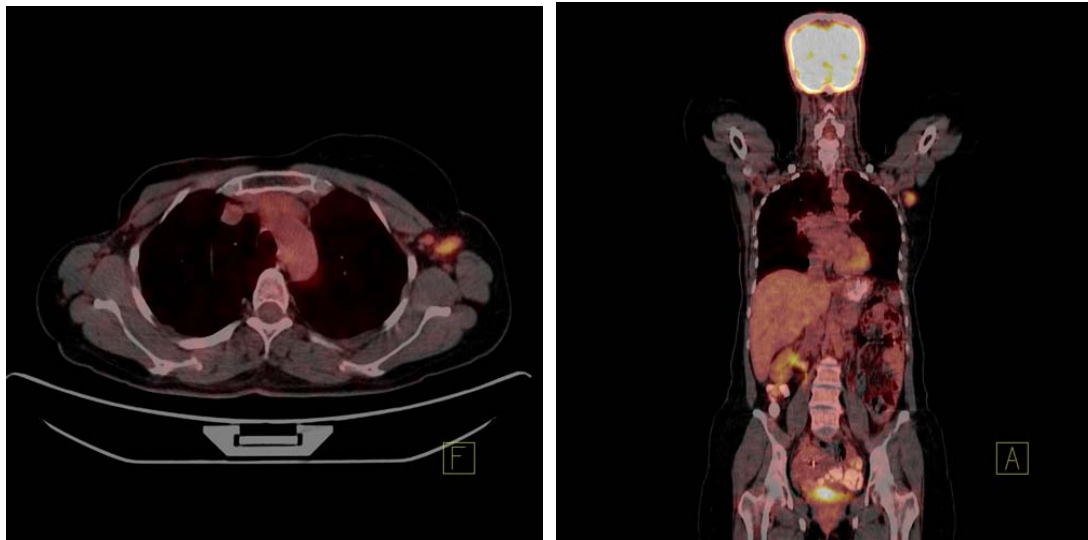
PET-CT imaging revealed left axillary (14 mm, SUV max 3,6) and left intramammary (16 mm, SUV Max 5,6) lymphadenopathy.
